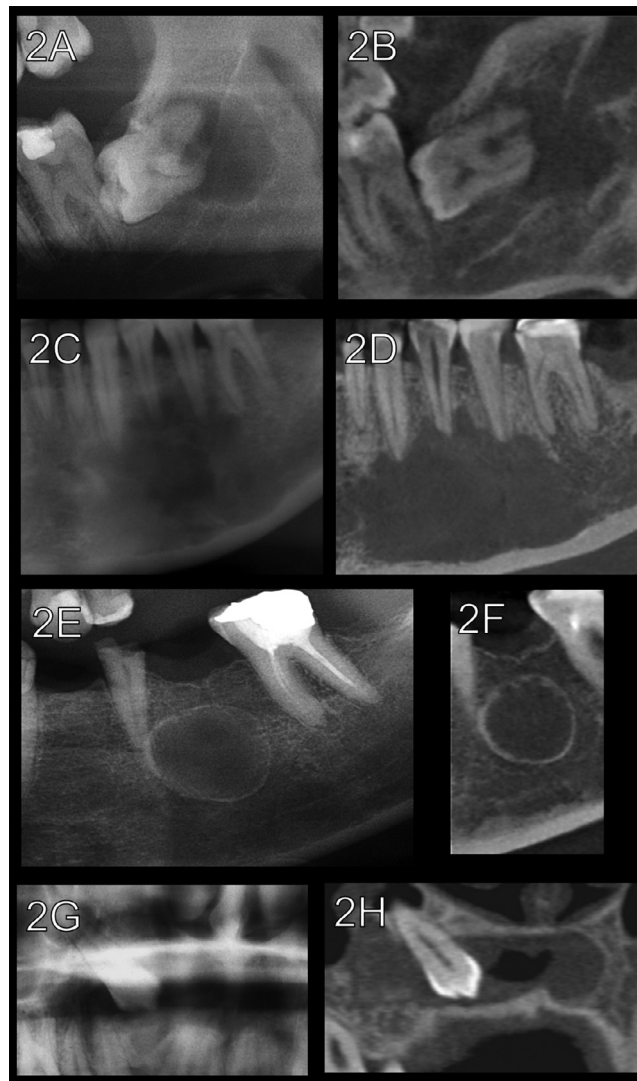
Cropped images of panoramic radiography (PR) (left side of each pair) and cone beam computed tomography (CBCT) (right side of each pair) comparing the imaging modalities. (A, B) Disagreement between the imaging modalities regarding the presence of peripheral cortication (PC), which was interpreted as present in (A) whereas in (B) no cortical border was detected with CBCT. This represents a false-positive interpretation. (C, D) Absence of cortication on the distal periphery was noted in both imaging modalities (true negative). There is contact between the lesion periphery and the inferior border of the mandible. (E, F) Agreement between both modalities for the presence of PC, producing a true-positive interpretation. Continuity in all peripheral limits of the lesion was also detected on PR and CBCT. (G, H) Disagreement between imaging modalities for the mesial periphery of the lesion, in which PC was scored as absent on PR but was detected on CBCT (false negative).
